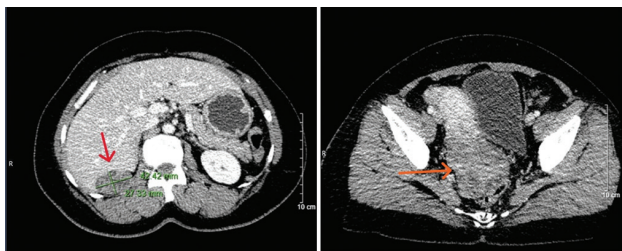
Contrast-enhanced axial computed tomography images demonstrating two enhancing soft-tissue masses. (Left) A well-enhancing peritoneal implant measuring approximately 42×29 mm is located in the right subphrenic space, between the right hepatic lobe and the right hemidiaphragm (red arrow). (Right) A heterogeneously enhancing pelvic mass measuring approximately 65×64 mm with ill-defined borders abuts the posterior cervical wall and the anterior wall of the upper rectum (orange arrow), suggestive of local invasion or dense adhesions.
